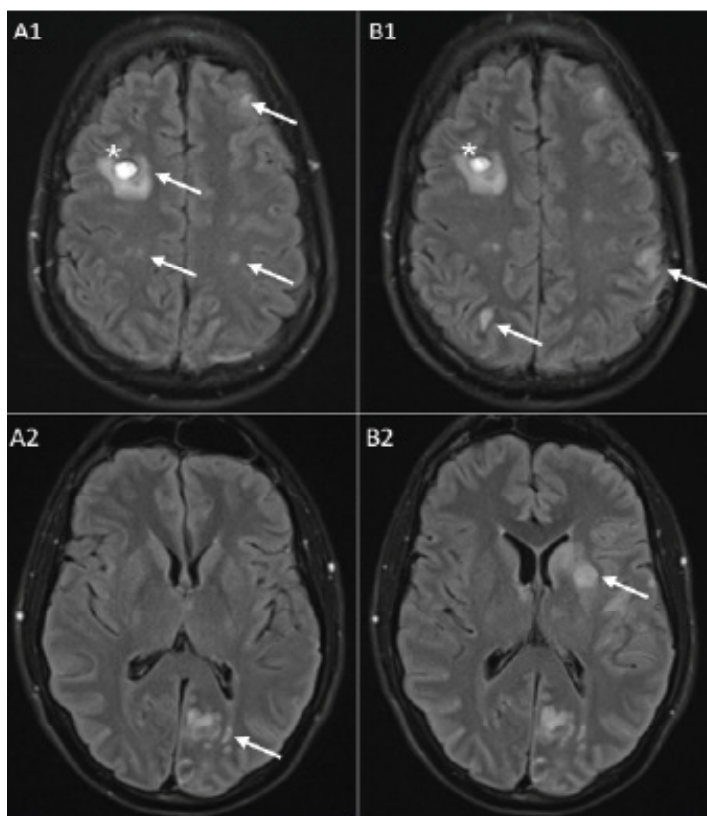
Images from a FLAIR MRI of the brain without contrast: A1 and A2 from MRI on hospital day two, show multiple parenchymal signal abnormalities throughout the cerebral hemispheres bilaterally compatible with multifocal infarcts from septic emboli (see arrows). A focus of intraparenchymal hemorrhage within the right frontal lobe measuring 1 cm is seen in A1 and redemonstrated in B1 with stable appearance (*). B1 and B2 are from MRI on hospital day 4 with new, left middle cerebral artery distribution infarcts involving the left basal ganglia, insula, corona radiata, and parietal lobe seen in B2 that were not seen prior when compared to A2. New infarcts are labeled with arrows in B1 and B2.
